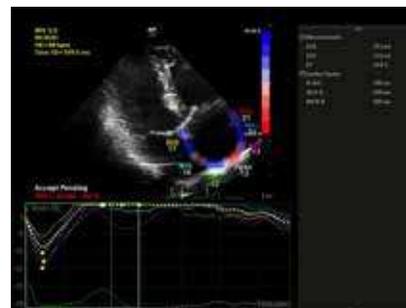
Right atrial speckle tracking echocardiography.
